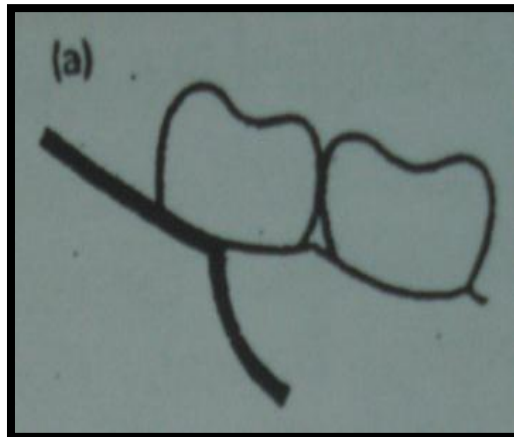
TRACED PANORAMIC RADIOGRAPH TO
